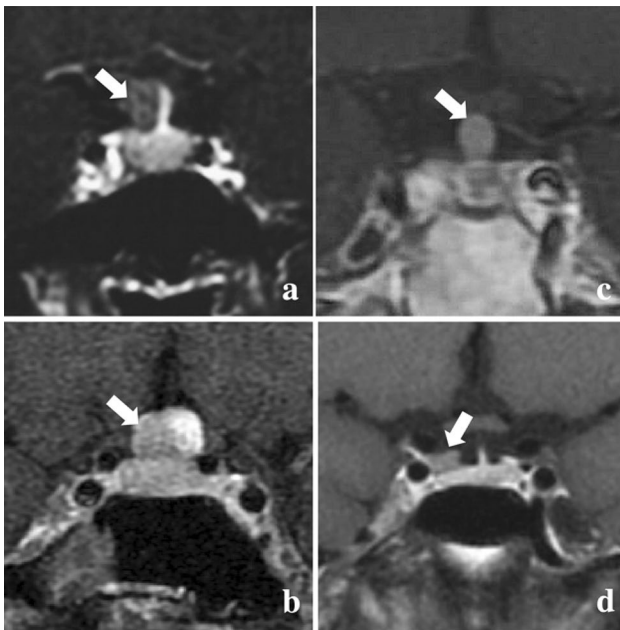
MRI presentations of Patients 4 (a), 5 (b), 6 (c) and 7 (d). White arrows show suspicious tumors
